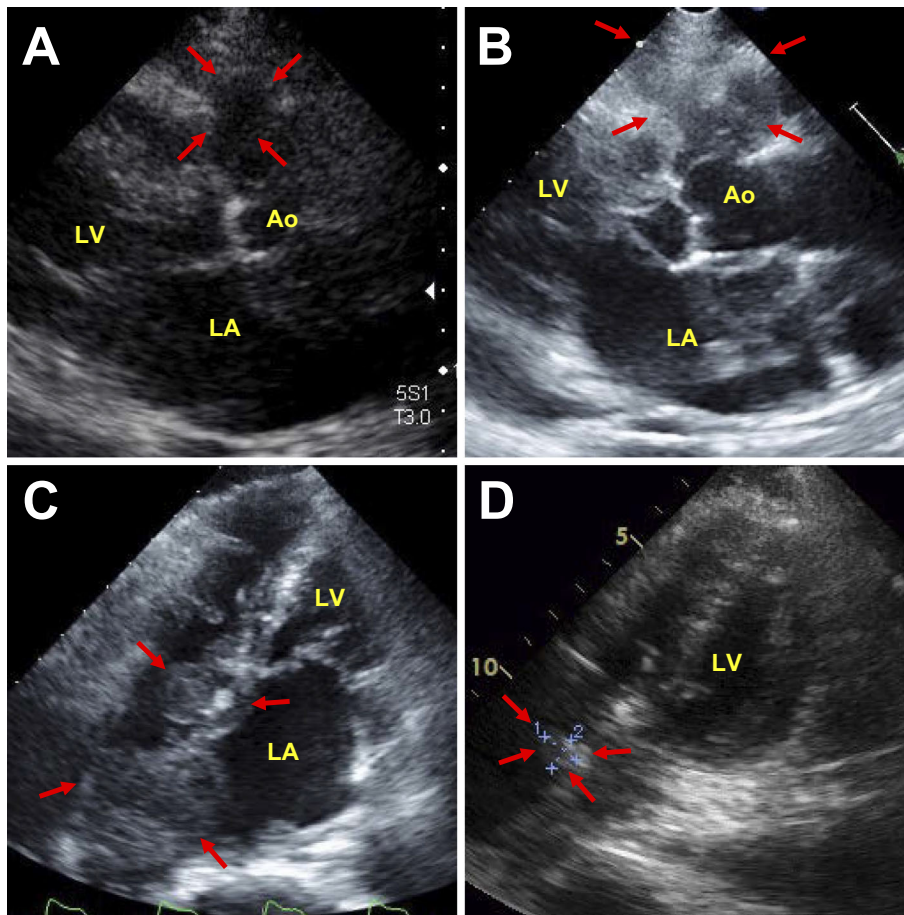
A) Transthoracic echocardiogram of the long-axis view showing an abnormal mass adjacent to the sinus of Valsalva (arrows). B) The size of the abnormal mass was significantly increased at subsequent echocardiographic examinations (arrows). C) Apical four-chamber view revealing a massive tumor involving the right atrium and the interatrial septum (arrows). D) A significant reduction in the size of the tumor was observed after chemotherapy with rituximab (arrows). Ao: aorta, LA: left atrium, LV: left ventricle
